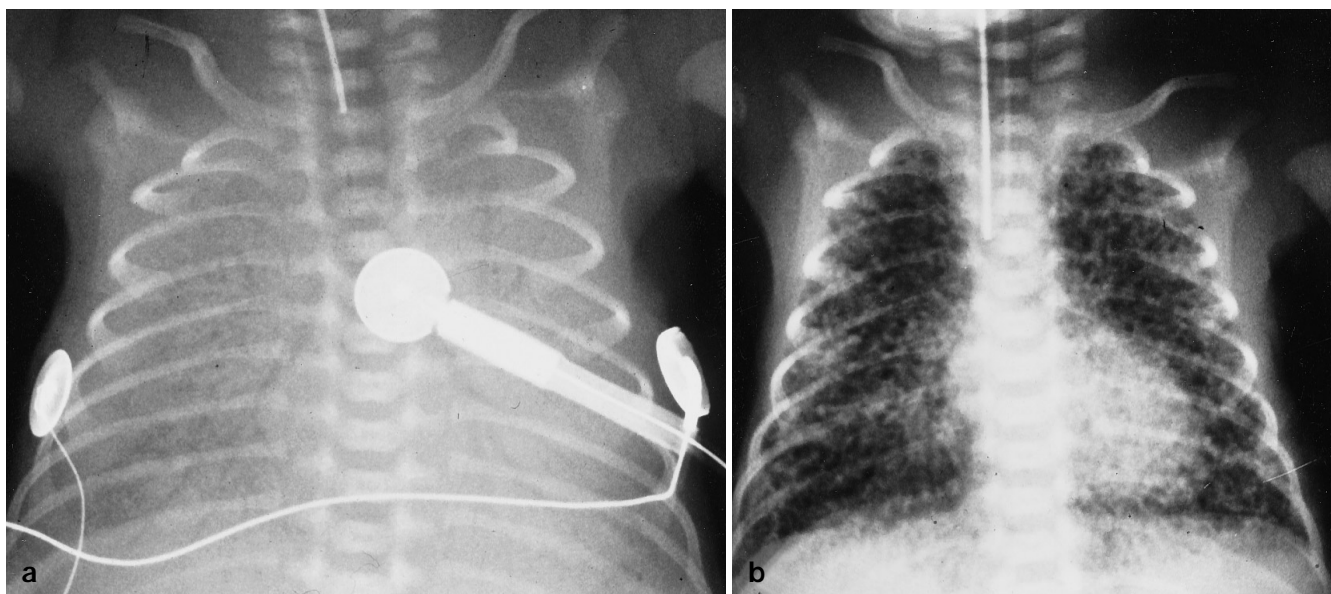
Preterm infant (GA 29 weeks, 1210 g) with severe RDS: chest radiographs a before and b 24 h after surfactant treatment show severe pulmonary interstitial emphysema after surfactant treatment
